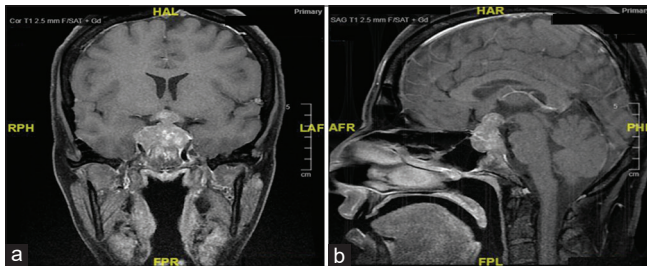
Baseline pituitary magnetic resonance imaging, coronal (a) and sagittal (b) images show evidence of an intrasellar mass with suprasellar extension, compressing and displacing the optic chiasm. Invasion to the cavernous sinus is noted, bilaterally with invasion of the clivus and destruction of the posterior clinoid
